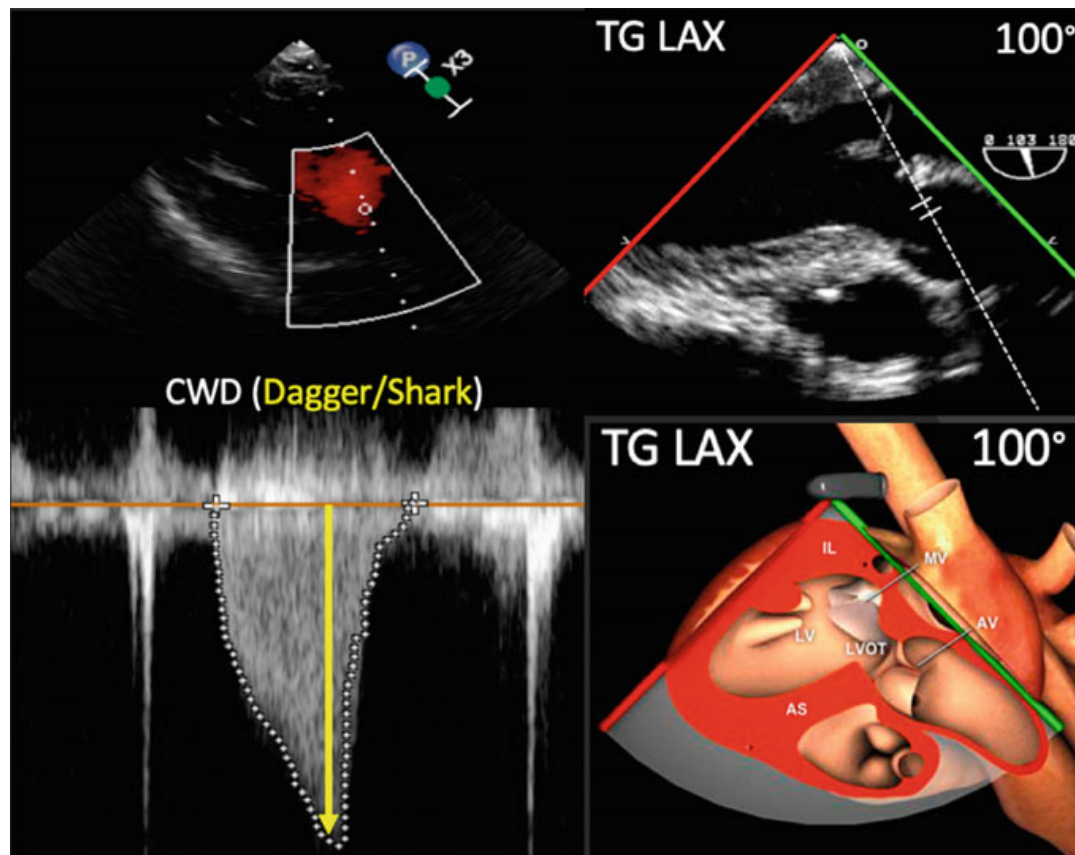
Transesophageal echocardiography (TEE) long axis (LAX) transgastric view to determine dynamic subaortic obstruction of the left ventricle outflow tract (LVOT) due to systolic anterior motion (SAM) of the anterior mitral valve leaflet, by continuous wave Doppler (CWD). Modified from pie.med.utoronto.ca
